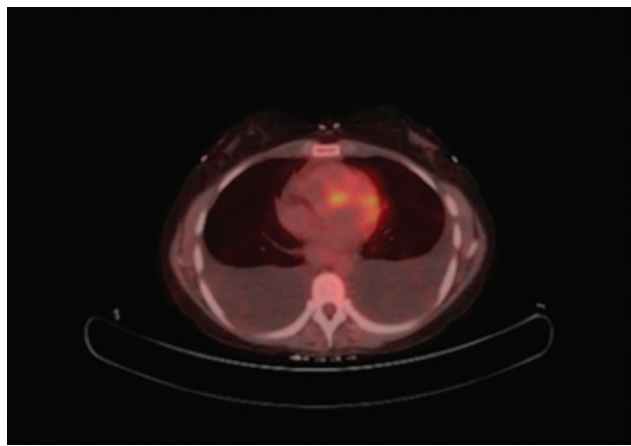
Positron emission tomography/computed tomography scan of the chest showing bilateral pleural effusions.
